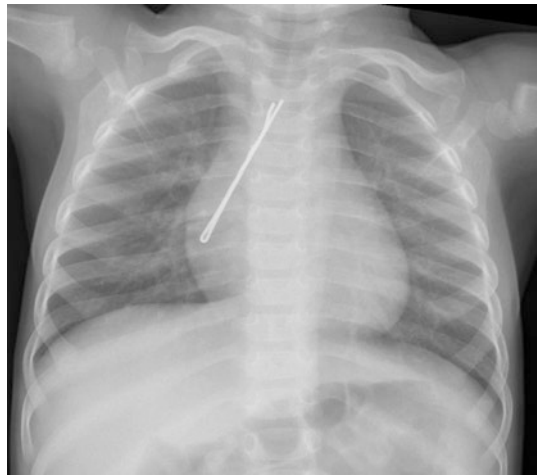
Chest radiograph in a child who presented with stridor which shows a foreign body, a hair-clip, lodged in the right main bronchus
